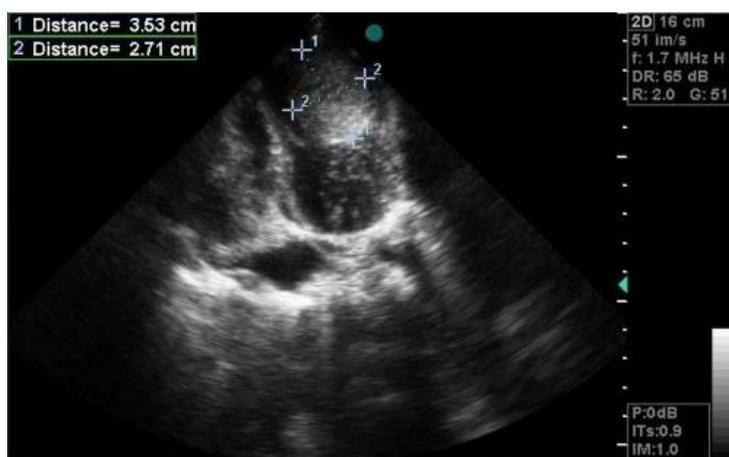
preoperative echocardiography showing an echogenic mass in the LV apex.
